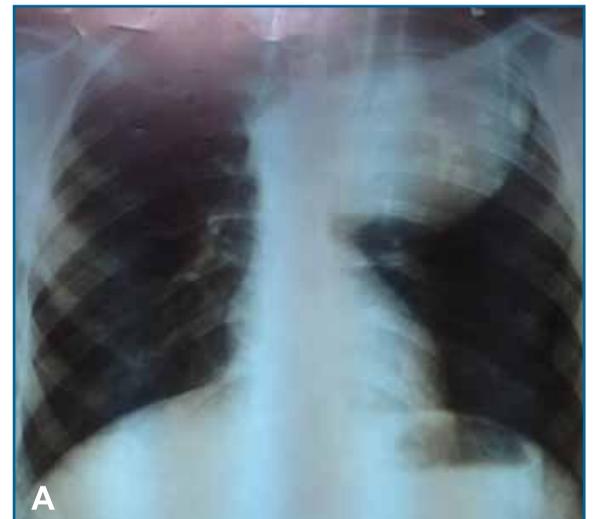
Chest X-ray and CT scan of the chest: (a) a large densely radio-opaque shadow in the left upper lobe area; (b) heterogeneously enhancing mass with central hypodensity which indicates necrosis.
